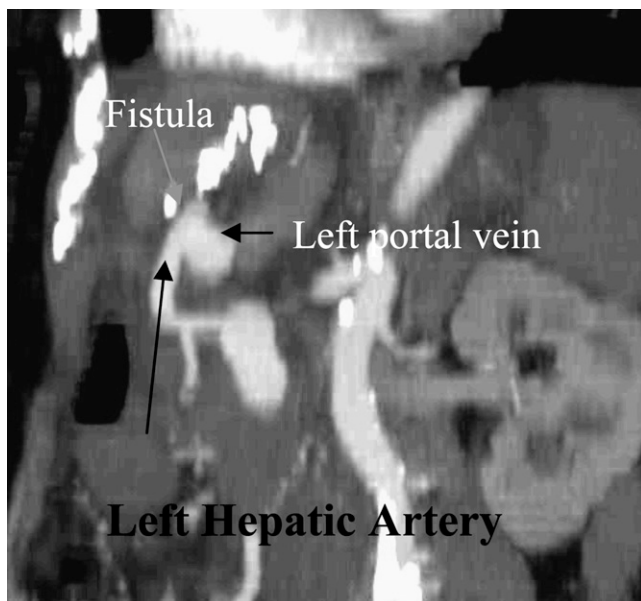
Sagittal oblique multiplanar reconstruction of hepatic CT angiography showing the APF.
